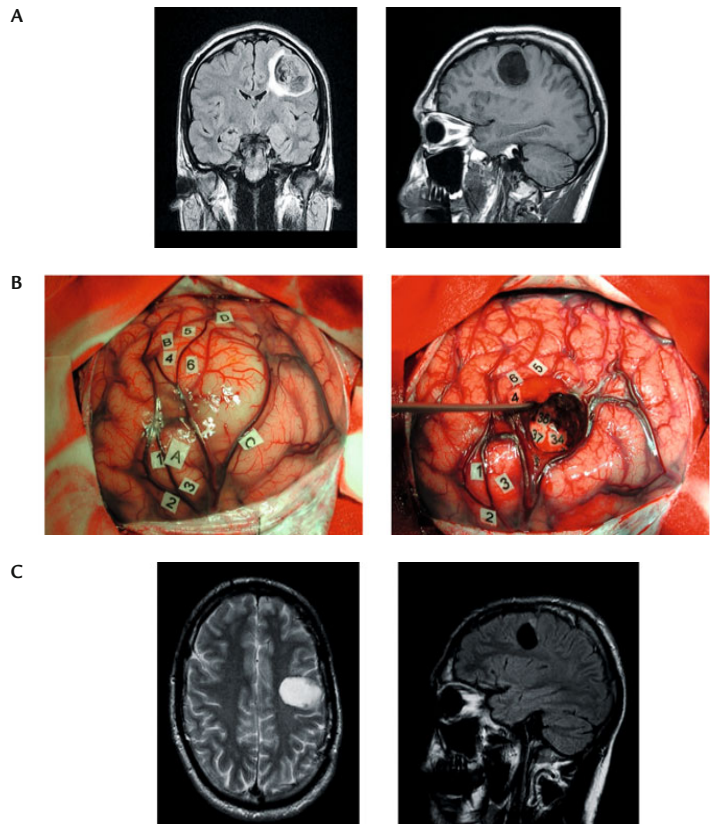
(A) Preoperative coronal FLAIR-weighted MRI (left) and sagittal T1-weighted MRI (right) showing a left precentral glioma involving the middle frontal gyrus. (B) Intraoperative cortical mapping: tags *A*, *B*, and *C* are tumor boundaries as shown by intraoperative ultrasonography. 1–3 Primary motor area of the hand, 4 speech arrest with facial movements, 5 and 6 speech arrest in the ventral premotor cortex. On the right, subcortical mapping shows the resection cavity with no margin between functional limits and tumor, thanks to a subpial dissection along the precentral sulcus (spatula). The subcortical functional boundaries were: the pyramidal fiber track of the hand at the bottom of the sulcus (37) and fibers coming from the ventral premotor cortex inducing anarthria (36), both constituting the so-called “vertical connectivity” of projection fibers, as well as phonemic paraphasia elicited by stimulation over the arcuate fascicle, i.e., long-distance association pathways, or “deep connectivity” or “horizontal connectivity” (34). (C) Post-operative axial T2-weighted MRI (left) shows surgical cavity, which is directly in contact with the precentral sulcus, where subpial dissection was performed with no residual tumor at this level and no margin. Sagittal FLAIR-weighted MRI (right) shows inferior limit of the surgical cavity directly in contact with the arcuate fascicle, which lies just above the insula (Reproduced from [26])
